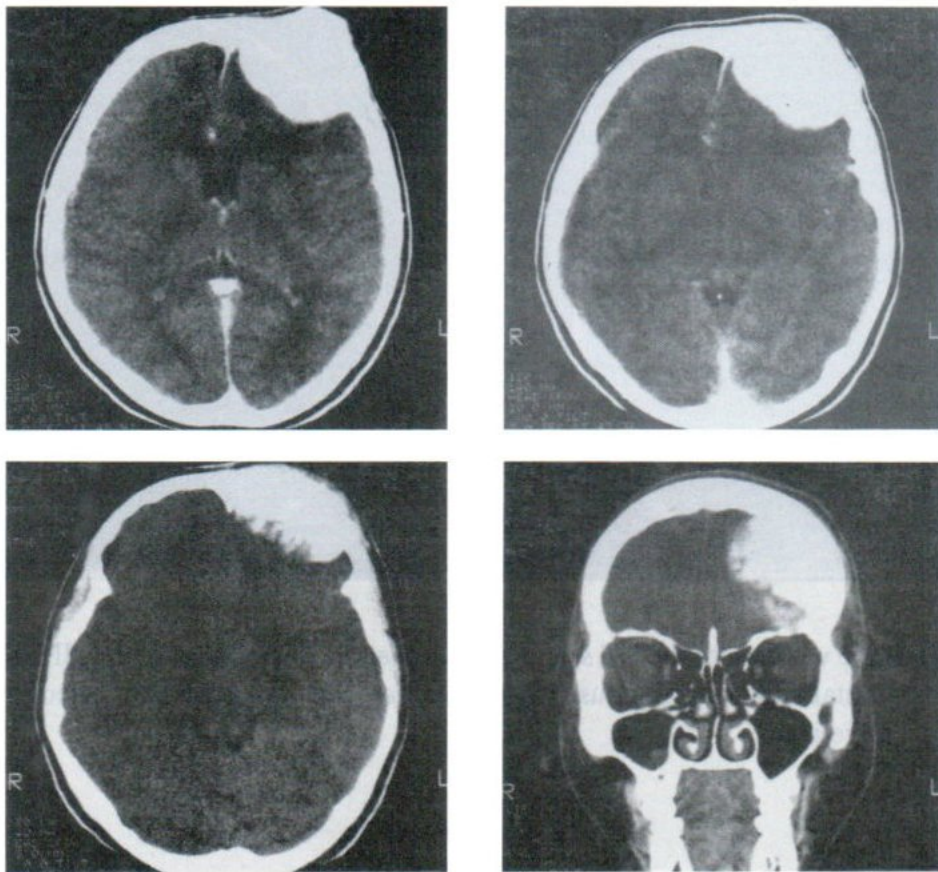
Case 1. Soft tissue window of the CT scan of the lesion showed that the nearly entire part of the mass was bony dense.
